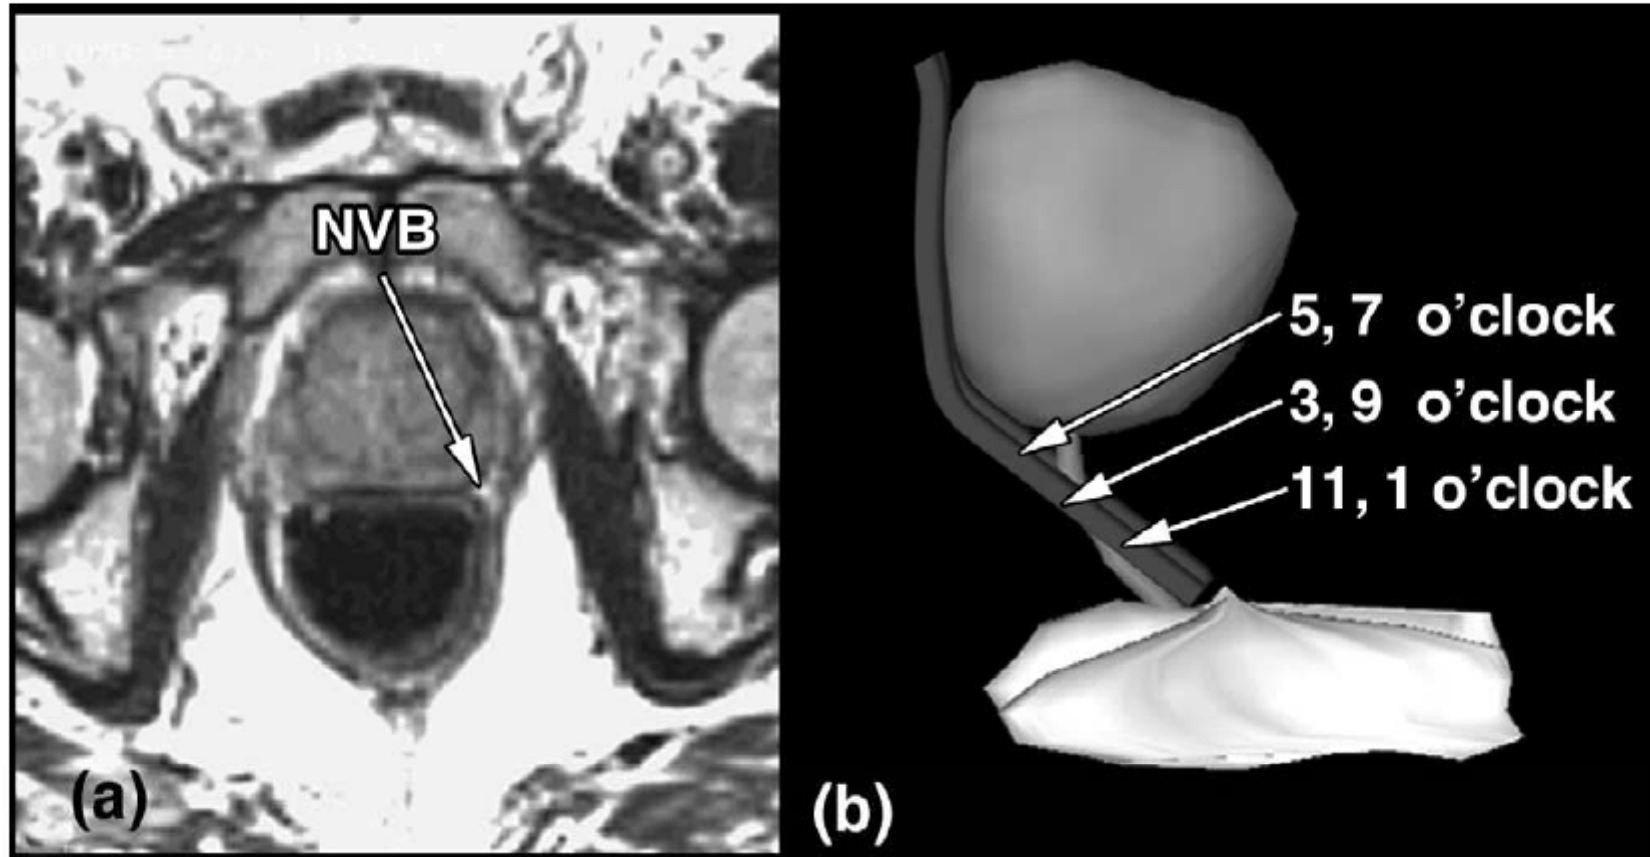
Neurovascular bundle (NVB) and terminal branches. (a) Axial magnetic resonance imaging. (b) Three-dimensional reconstruction with cavernosal nerve defined by relationship to membranous urethra.
